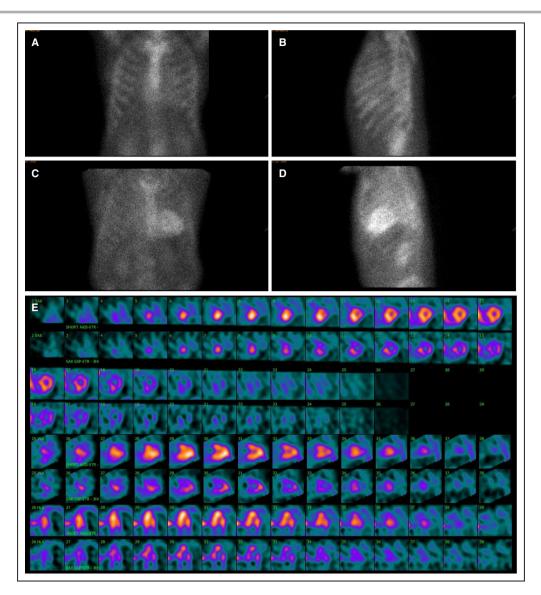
Technetium-99m-pyrophosphate planar and SPECT images for V122I carrier without ATTR-CM and V122I carrier with ATTR-CM.
